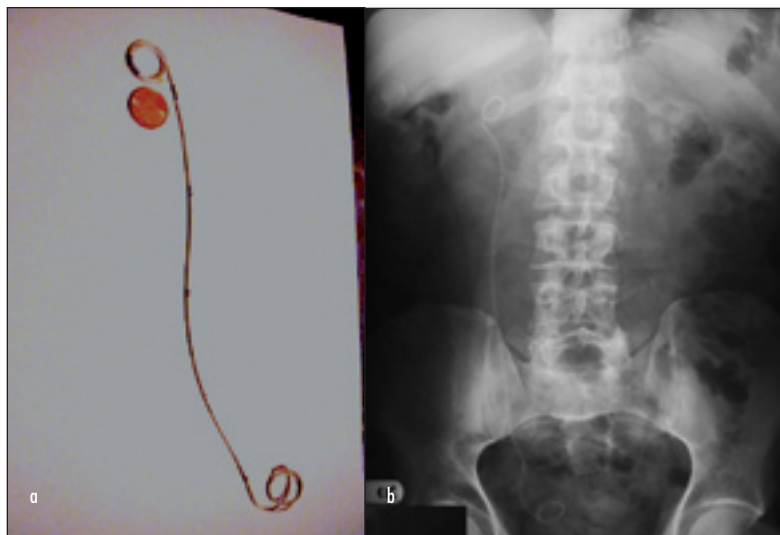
a. A typical ureteric stent. b. A kidney-ureter-bladder X-ray showing the stent correctly in situ, with proximal coils in the kidney, the main length of the stent in the ureter and the distal coils in the bladder.
